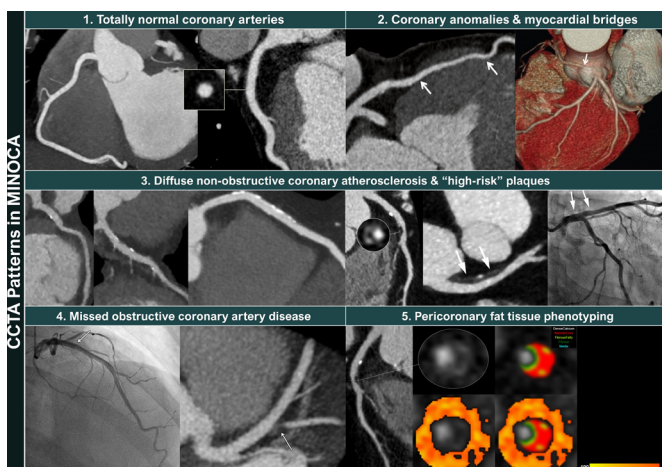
CCTA patterns in patients who initially diagnosed with MINOCA. (1) Totally normal coronary arteries, (2) coronary artery anomalies and myocardial bridges, (3) diffuse non-obstructive coronary atherosclerosis and 'high-risk' plaques, (4) missed obstructive coronary artery disease and (5) pericoronary fat attenuation profiling. CCTA, cardiac CT angiography; MINOCA, myocardial infarction with non-obstructive coronary arteries.
